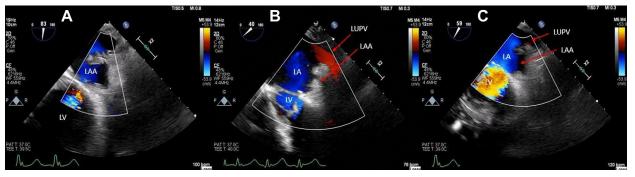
A series of images from a midesophageal two-dimensional TEE with color flow Doppler showing the LAA throughout the case. (A) Two-chamber view of the LAA prior to ligation and inversion. (B) Four-chamber view of the LAA after ligation and inversion. (C) Mitral commissural view of the ligated LAA after spontaneous resolution of the inversion. *Arrows* point towards the LAA and LUPV. *LUPV*, Left upper pulmonary vein.
